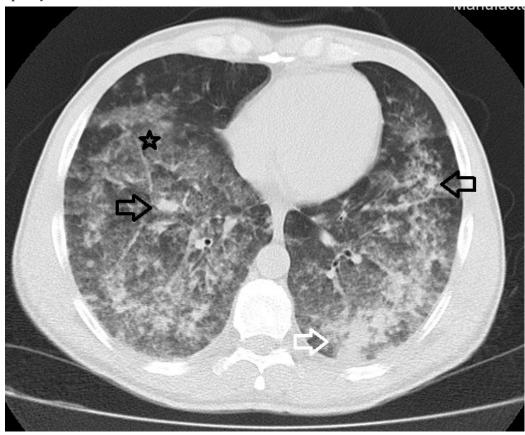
Chest CT performed 24 hours after admission (axial view). Black star – patchy ground-glass opacity. Black arrows – nodules with a surrounding halo of ground-glass opacity. White arrow – area of consolidation.
